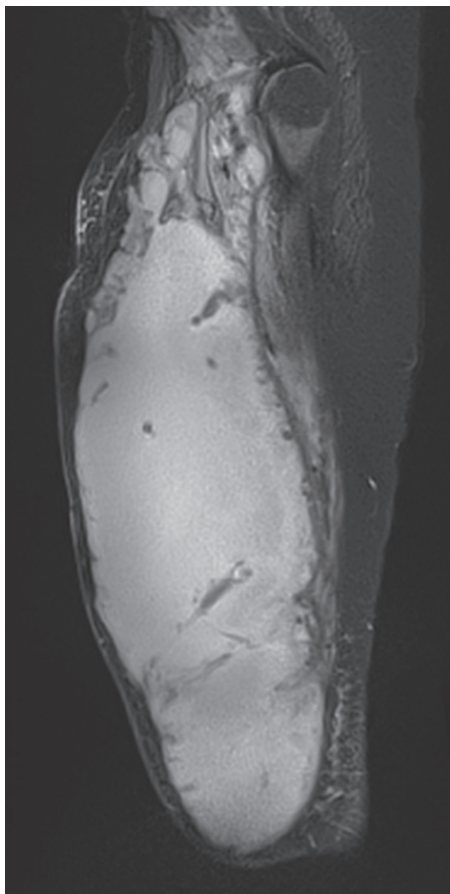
Sagittal T2-weighted MRI revealed the same liquid collection from the root of anterior thigh to the inferior limit of the right knee
